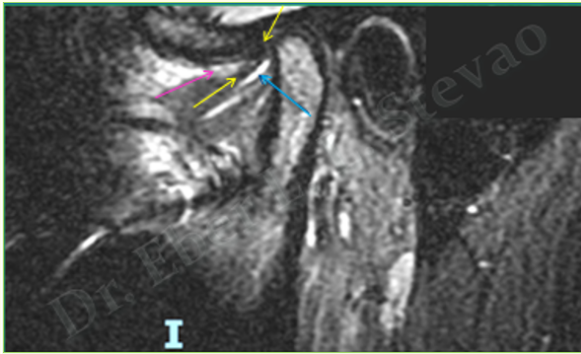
MRI of the right TMJ on sagittal view. This image only confirms the findings on figure 5. *Red arrow:* effusion present in the inferior articular space. *Yellow arrows:* anterior and posterior limits of the articular disc. *Magenta arrow:* discrete effusion inside the superior articular space on the right TMJ.
